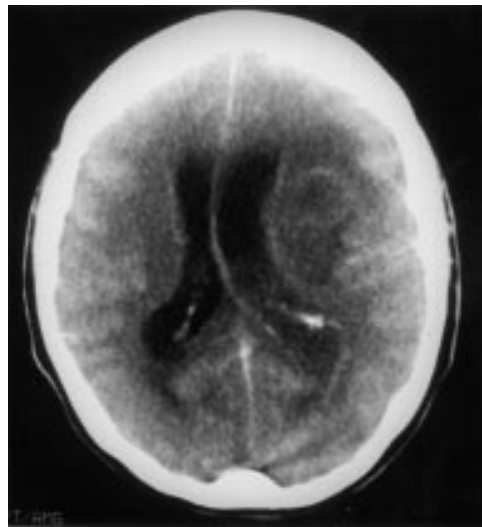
Computed tomography of the brain at the initial presentation.
